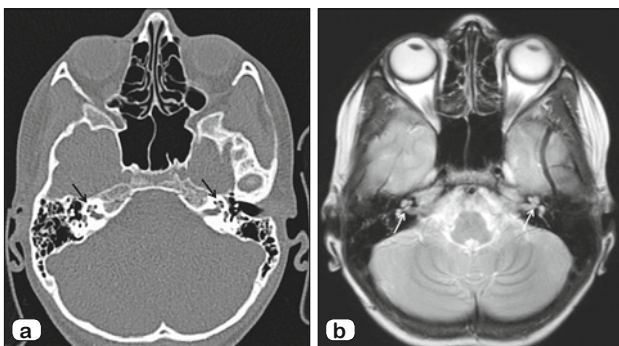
Brain and temporal bone CT (a) and T2 weighted MRI (b) scans in axial plane demonstrating normal inner ear anatomy (arrows).
